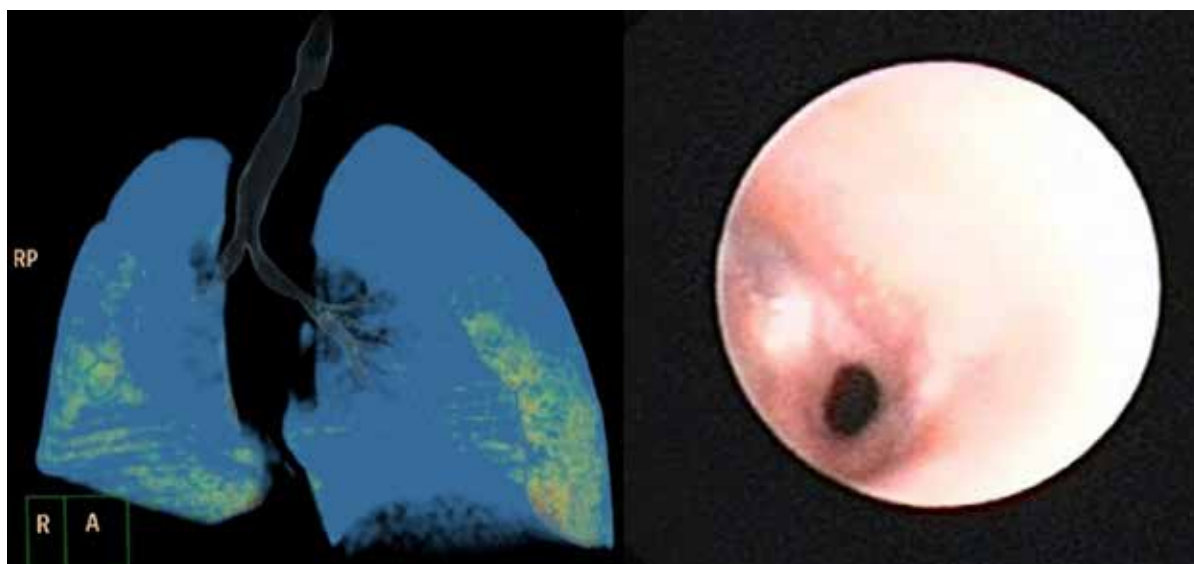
Chest CT-scan reconstruction: narrow segment of trachea and hypoplastic right lung
